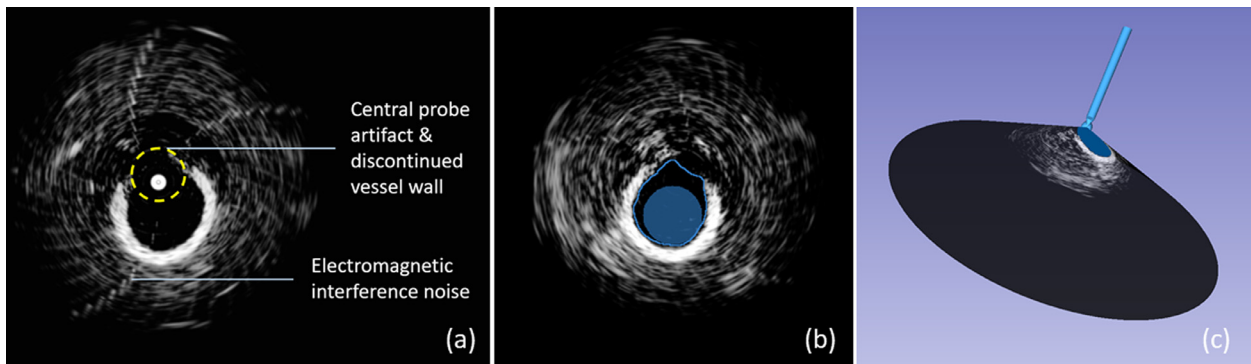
(a) Image data acquired using a framegrabber as a 2-D projection of the conical ultrasound. (b) Lumen segmentation (boundary) achieved using the initial seed (solid). (c) Conical reconstruction of the ultrasound image and the lumen segmentation.
